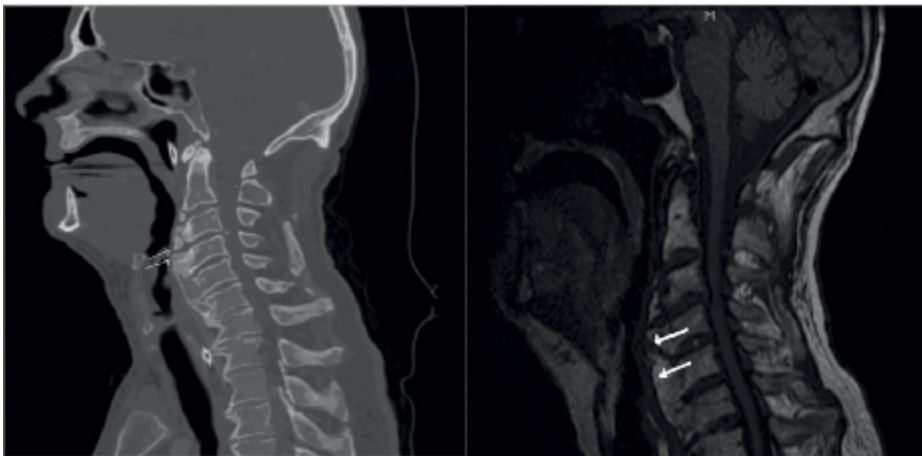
Sagittal CT (left) and MRI (right) of the neck demonstrating radiographic features of Diffuse Idiopathic Skeletal Hyperostosis (DISH). Bridging osteophytes (arrows) from C3 to C6 contributing to mechanical compression of the esophagus and subsequent dysphagia. Adapted from: Ref. [7].*
